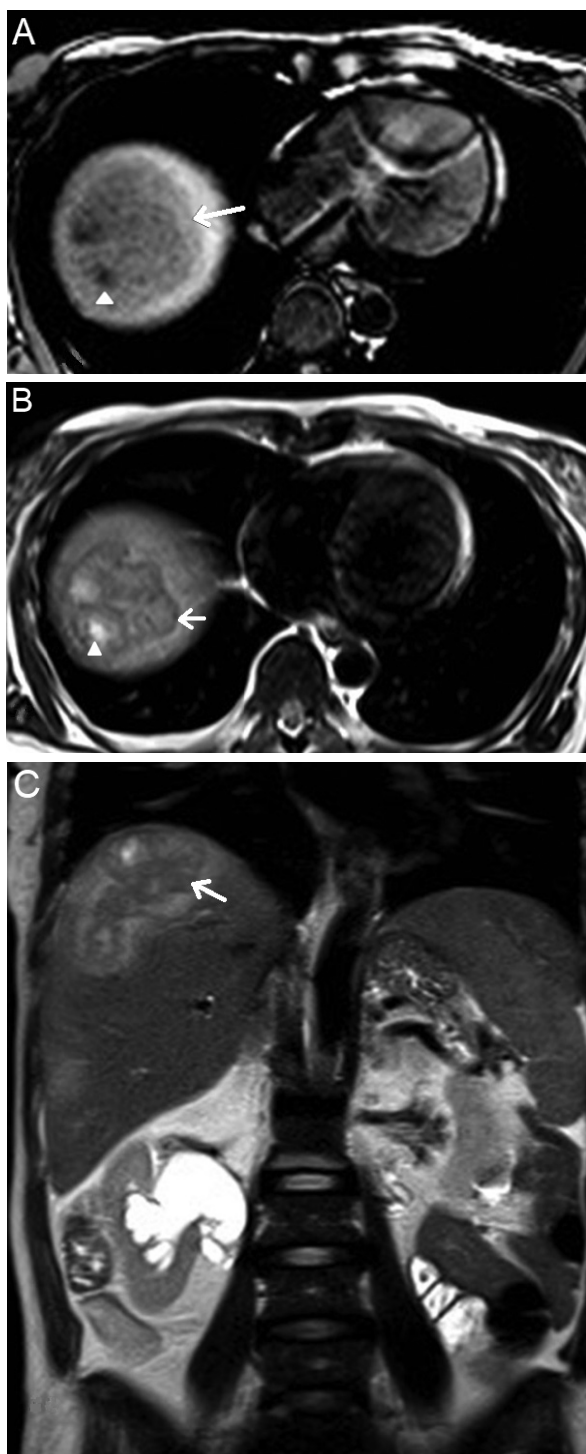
(A) T1WI and (B) T2WI magnetic resonance imaging utilising a 1.5T scanner without gadolinium administration; axial T1WI and coronal T2WI showed fibrosis rim of hepatic lesion (arrow) with low intensity, and an internal cystic component (arrowhead) with low intensity on T1WI and high intensity on T2WI. A peripheral rim of fibrosis was hypointense on both T1WI and T2WI (arrow). Surrounding T2 hyperintense oedema was noted. (C) Coronal T2WI showed a heterogeneously ill-defined high-signal-intensity soft tissue lesion in the right lobe of the liver (arrow) and right hydronephrosis.
